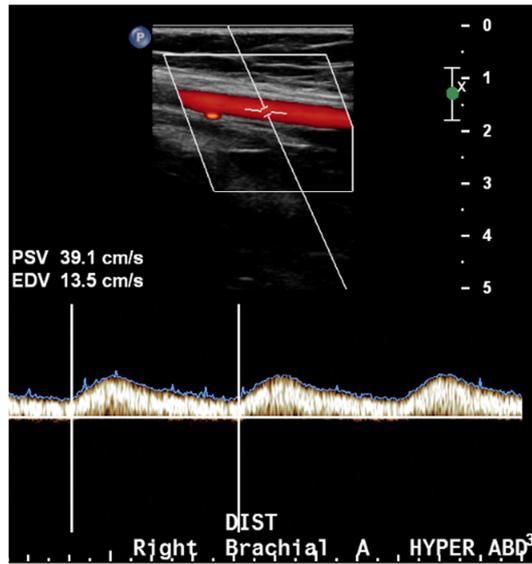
Low amplitude and diminished flow with hyperabduction of the right upper extremity during duplex ultrasonography.
